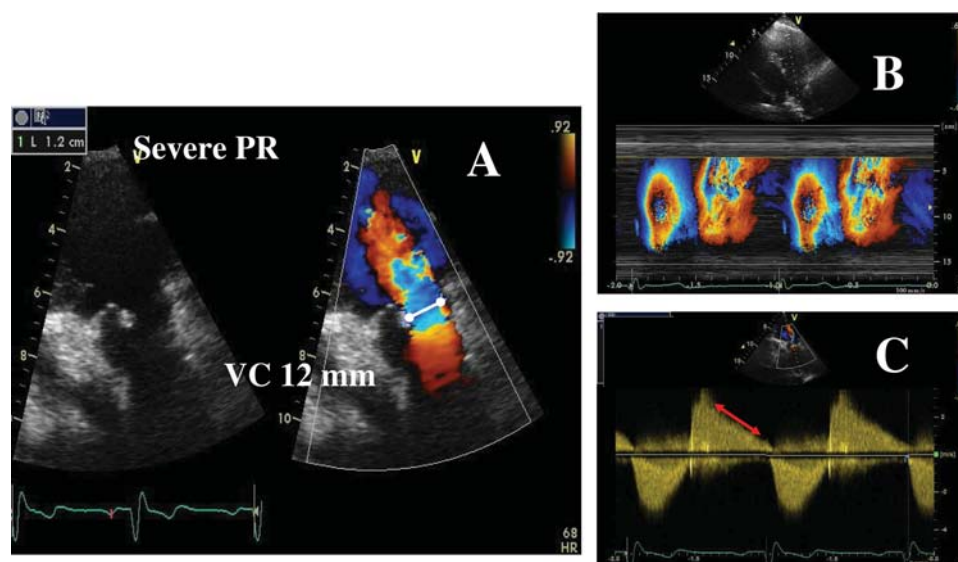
Example of a patient with a severe pulmonary regurgitation (PR). (A) Complete lack of valve coaptation (left) and measurement of the vena contracta width (VC) (right); (B) colour-coded M-mode depicting the time dependency of flow signal during the heart cycle; (C) continuous Doppler recording of PR showing a rapid flow deceleration during the diastole (red arrow) and increased systolic flow velocity (not related to concomitant pulmonary stenosis).
